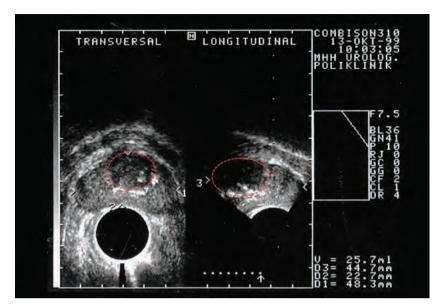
Transrectal ultrasound imaging of the prostate (TRUS) with a 7.5 MHz ultrasound array to measure total prostate and transition zone volume (left image: transverse section; right image: longitudinal section). The prostate appears as a hyperechogenic organ. The transition zone of the prostate (encircled) appears hypoechogenic compared to the central and peripheral zone. The border between the transition zone and other zone often contains hyperechogenic areas (stones). The patient of this example has a total prostate volume von 25.7 cm³.
